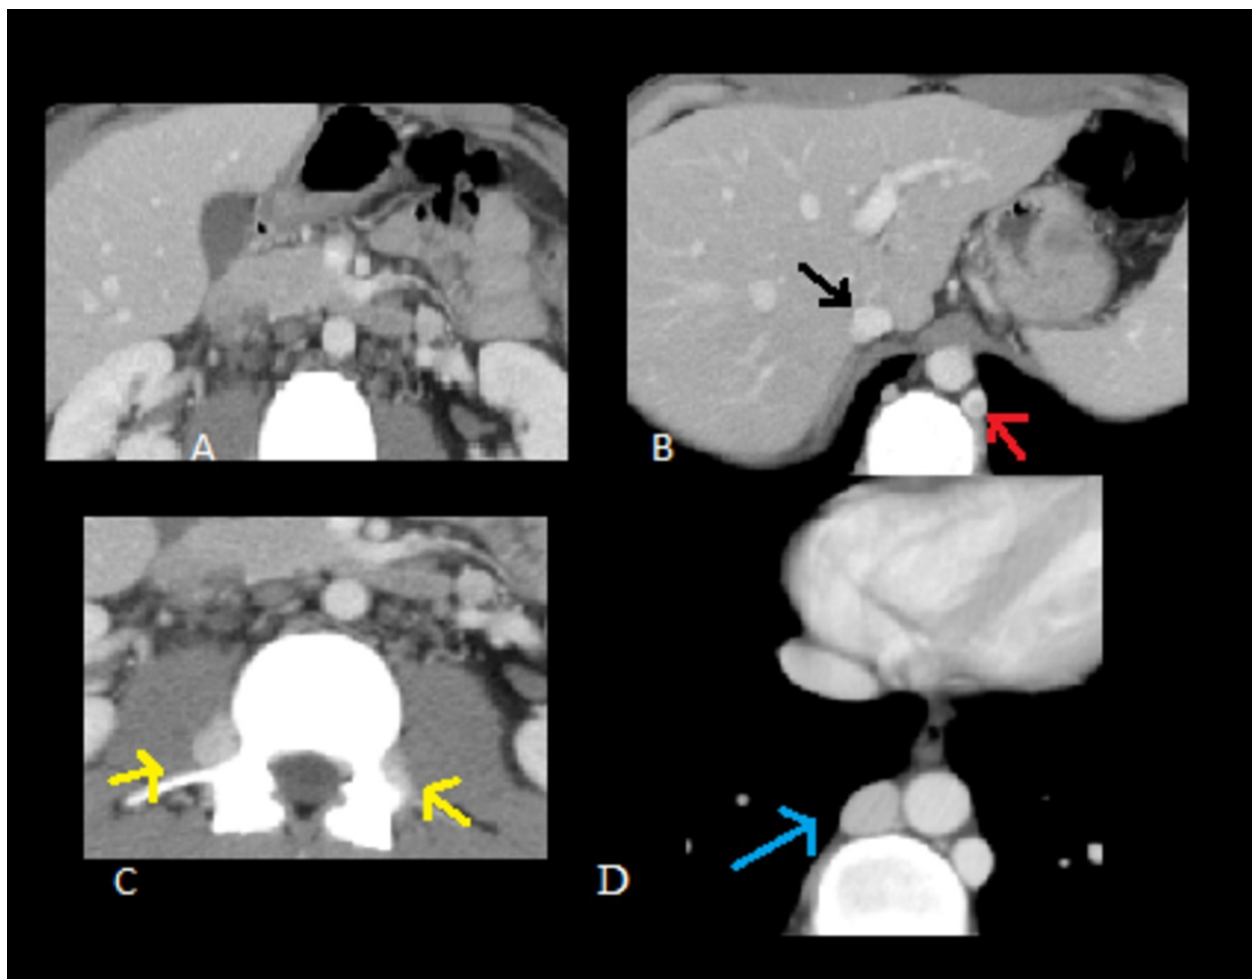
Absence of the infrarenal IVC with preservation of the suprarenal segment: Axial contrast-enhanced CT scans show absence of the infrarenal IVC (A). Note the prominent ascending lumbar veins (arrows in (yellow arrow) (C) and the patent
